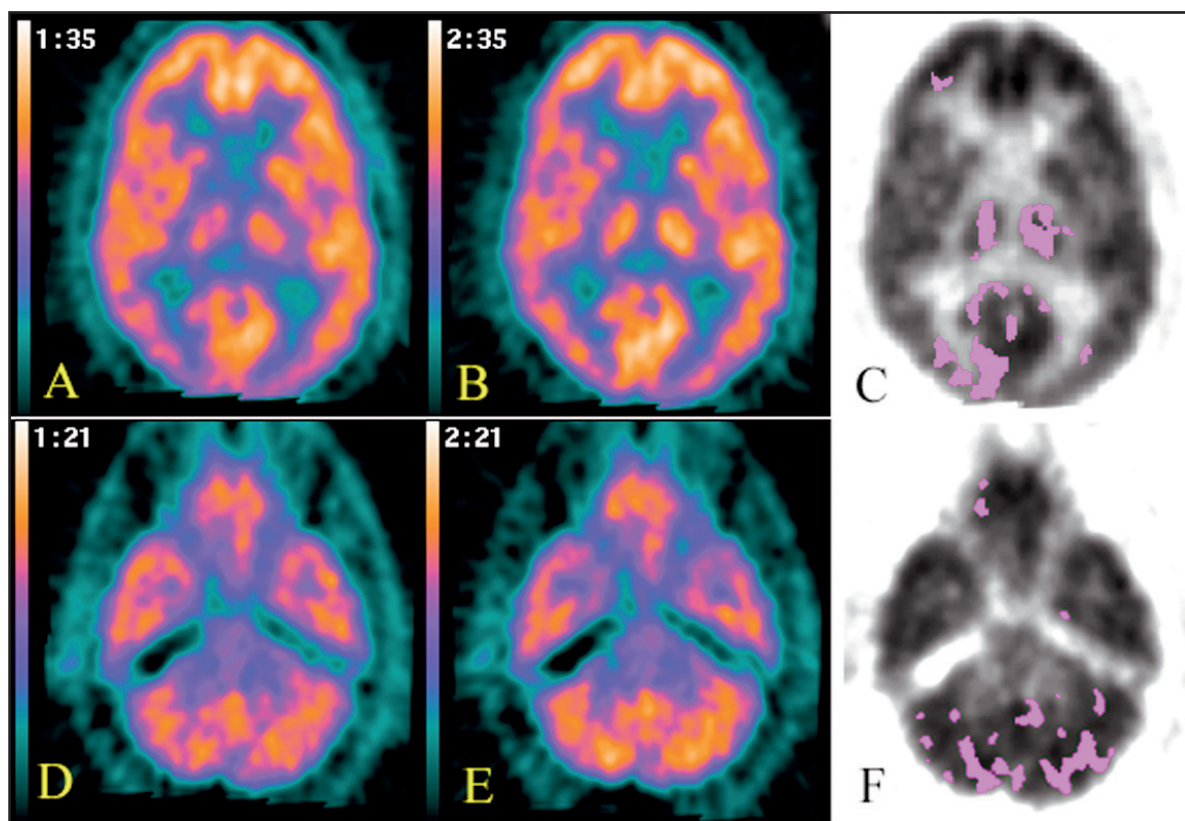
FDG-PET imaging during akathisia induced by 20 mg olanzapine daily (A, D), 6 months later (B, E) and subtraction analysis of both scans (C, F). Note the reduced metabolic activity in bilateral thalamus (A) and cerebellum (D) during olanzapine-induced akathisia compared to 6 months later when the patient was symptom free and off-medication (B and E, respectively). Subtraction analysis shows cortical regions with > 8% difference between both scans (C, F).
